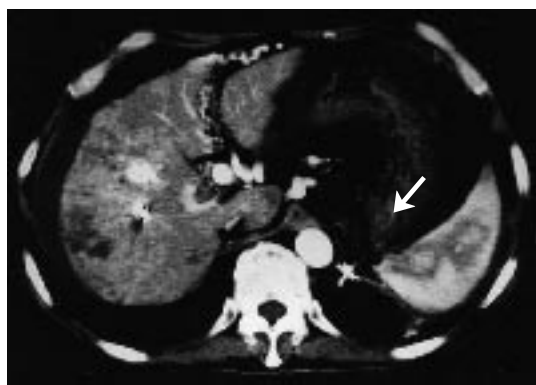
Contrast-enhanced CT showing thrombosed gastric varices (white arrow) on the following day.
